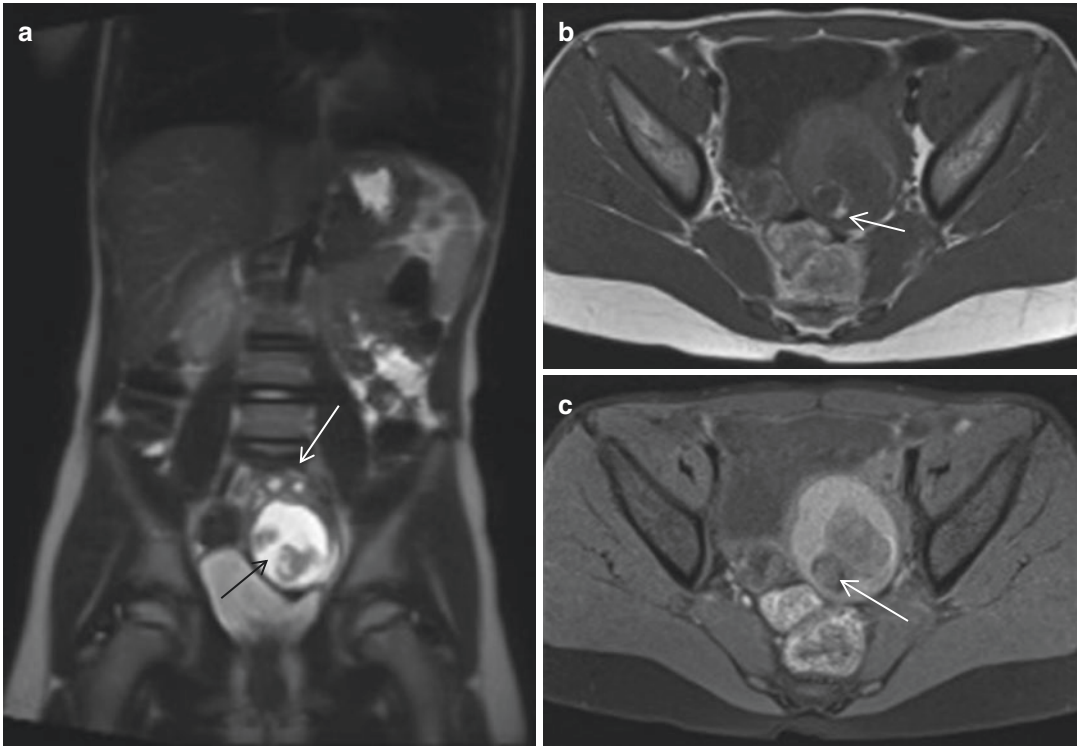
Ovarian torsion with an underlying tumor in an 8-year-old girl with a short history of cyclic cramping abdominal pain and vomiting. On coronal T2-weighted MRI the left ovary is shown, it is enlarged and there is a string-of-pearls configuration of the follicles, indicating torsion (*white arrow*). The ovary carries a well-circumscribed
